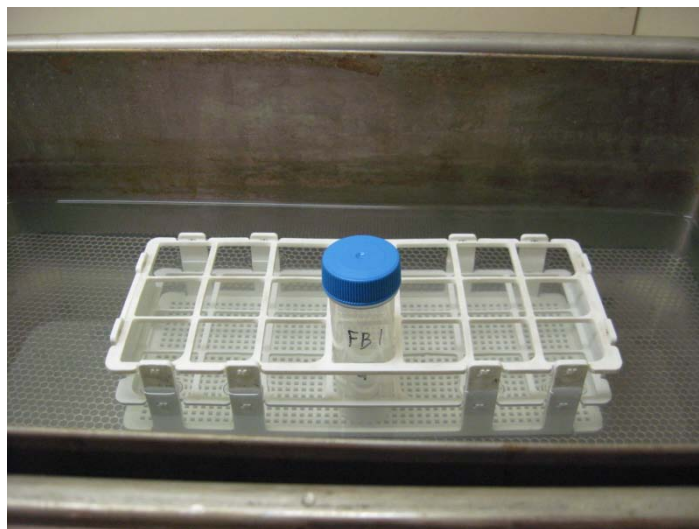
Filter in plastic extraction tube in tube rack placed in ultrasonic bath.
